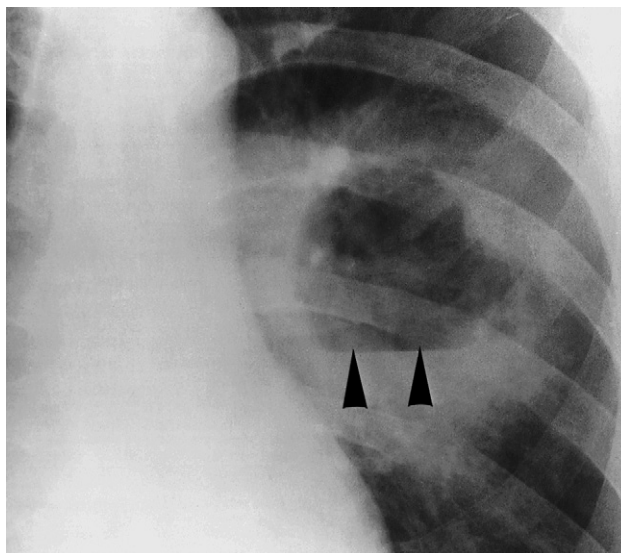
Fluid level (arrowheads) in a lung abscess. Fluid levels are only visible if the chest radiograph is taken with a horizontal x-ray beam.
